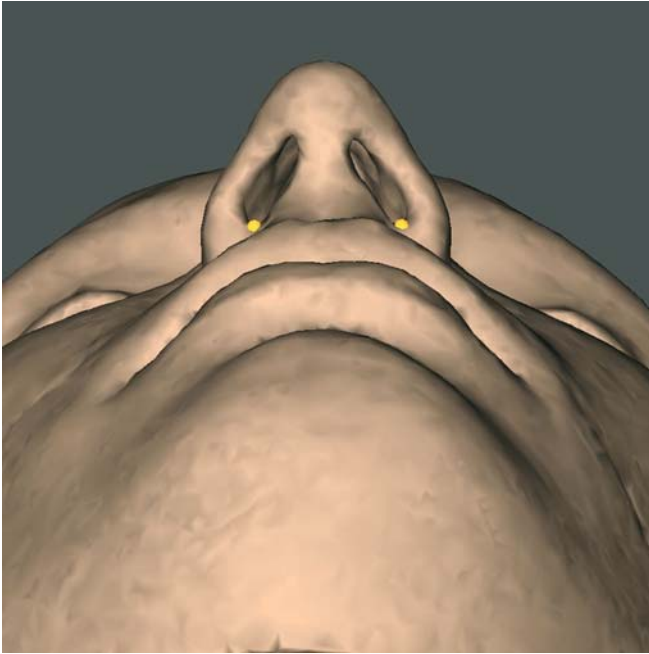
Nostril base point_r and nostril base point_l. Base view (3-D CT, patient K.C.)
